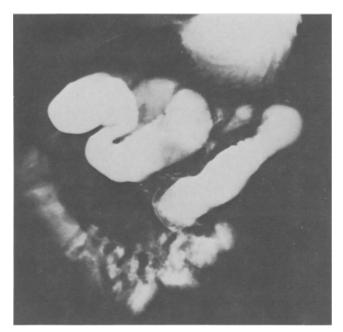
Small-bowel x-ray showing obstruction of upper jejunum.
